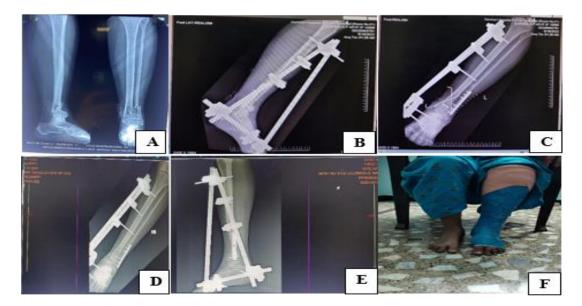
Case 1 (A) pre-operative radiograph; (B) immediate post-operative radiograph (lateral view); (C) immediate post-operative radiograph (AP view); (D) post-operative radiograph after k wire removal (AP view); and (E) ost-operative radiograph after k wire removal (lateral view); (F) PTB cast application and allowing guarded weight bearing after external fixator removal.
